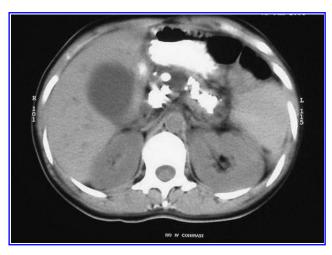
A computed tomography picture of pancreatic calcification.
